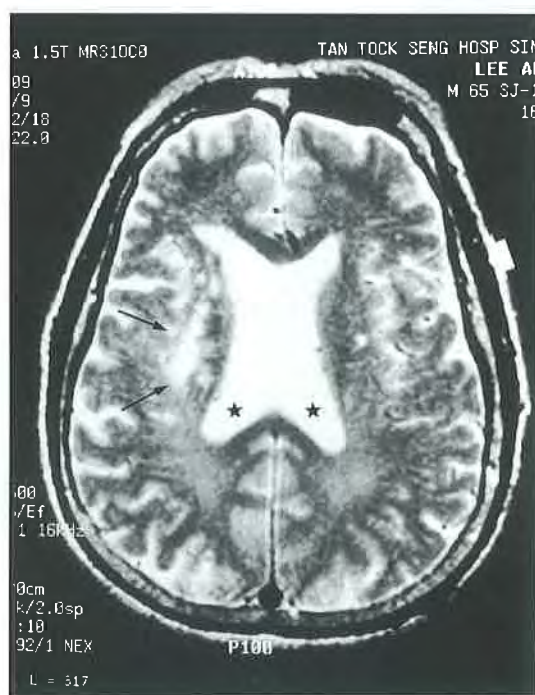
In a T2 weighted axial MRI image, the skull vault (white arrow) is black and the CSF in the ventricles is white (stars). The infarct in the right corona radiata appears as a bright lesion (black arrows)
